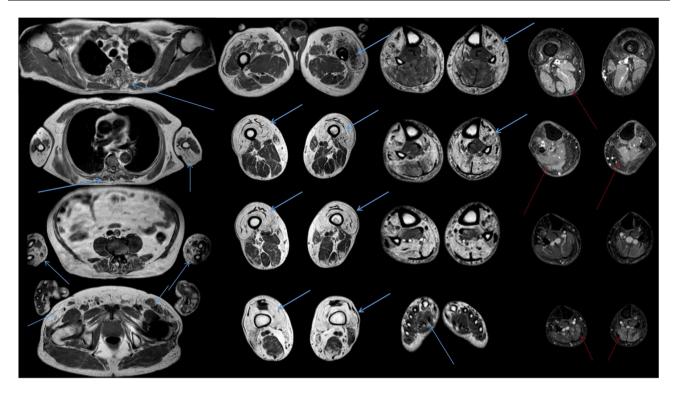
Whole-body muscle MRI in a patient with (Axial T2 Dixon "Fat" and "Water" images, Imaging Department, Raymond-Poincaré Hospital, AP–HP, 2022). Note the asymmetrical involvement of the quadriceps (most severe and common finding in this disease), the paraspinal muscles the forearms, the finger flexors and foot extensors distally. On "water" images, inflammation can be seen both in the muscle compartments affected and in the peri-muscular facias (red arrows).
